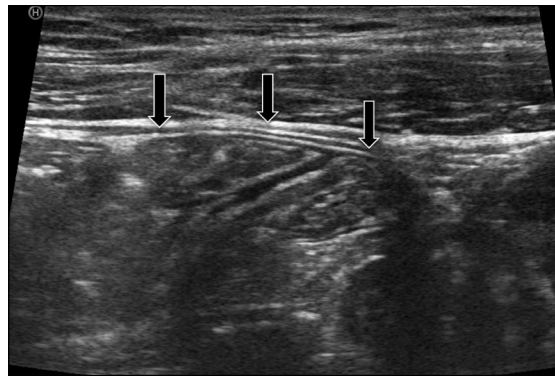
Gray-scale ultrasound image showing hyperechoic linear structure enveloping clustered bowel segments loops (arrows). Free fluid is not observed.
